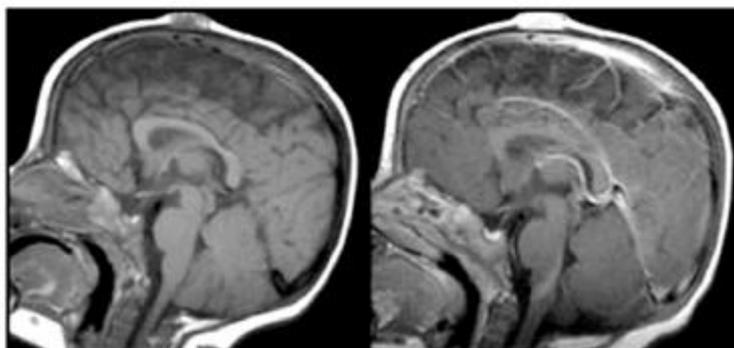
Case4, MRI sagittal T1WI and Sagittal T1WI Post gadolinium DTPA study showed evidence of sinus pericranii in frontal region.
